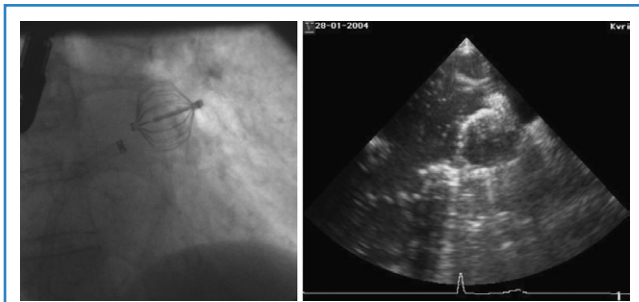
Left atrial appendage occlusion device as imaged by fluoroscopy and echocardiography.
